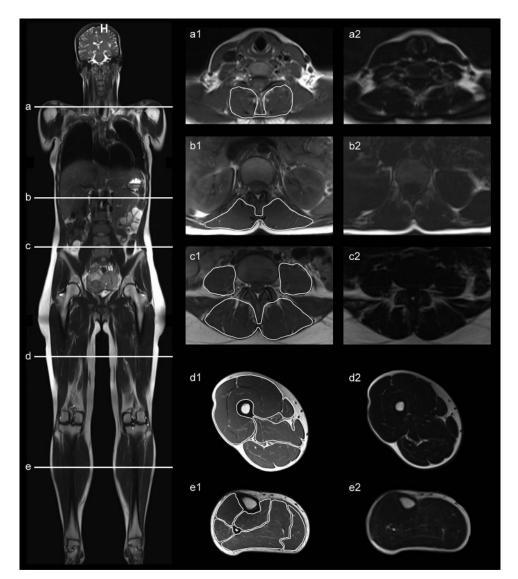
Mapping of back and leg muscles. (*Left*) The five chosen slices marked on a whole-body localizer (a–e). (*Middle*) Muscle mapping on T1-weighted images in cervical (a1), thoracic (b1), and lumbar (c1) regions of the back and the thigh (d1) and calf (e1). *Right* (a2–e2) Dixon fat images of the same regions as a1–e1.
